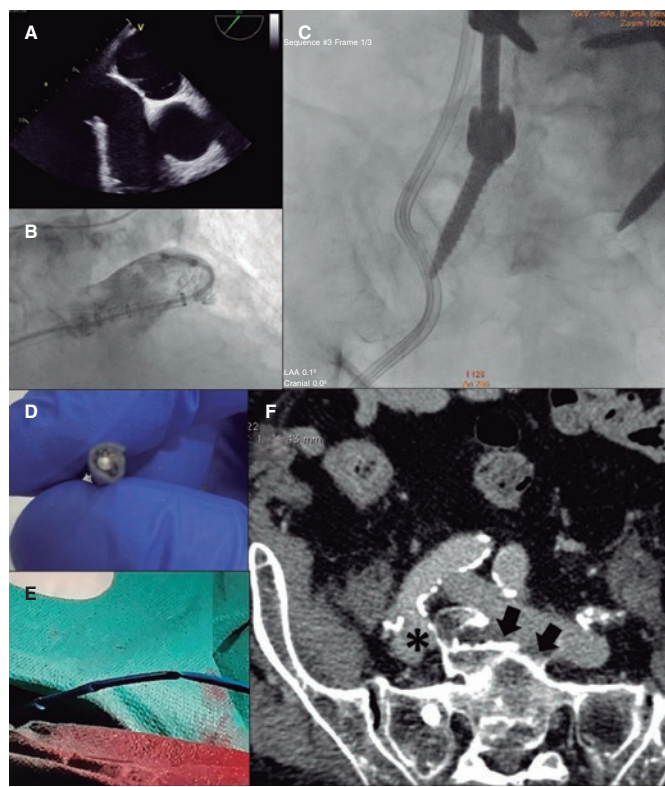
Limited contact pressure of transseptal system (A), and difficult maneuverability of the pigtail catheter (B) due to the severe torsion of the delivery catheter (C). Procedure stopped due to the impossibility of advancing a new device or guidewire (D, E). Computed tomography scan (F) of a compressed right iliac vein (asterisk) between the fracture and the homolateral common iliac artery. Presence of endofibrosis (arrows) and lack of cleavage plane between the left common iliac vein and the sacrum.
